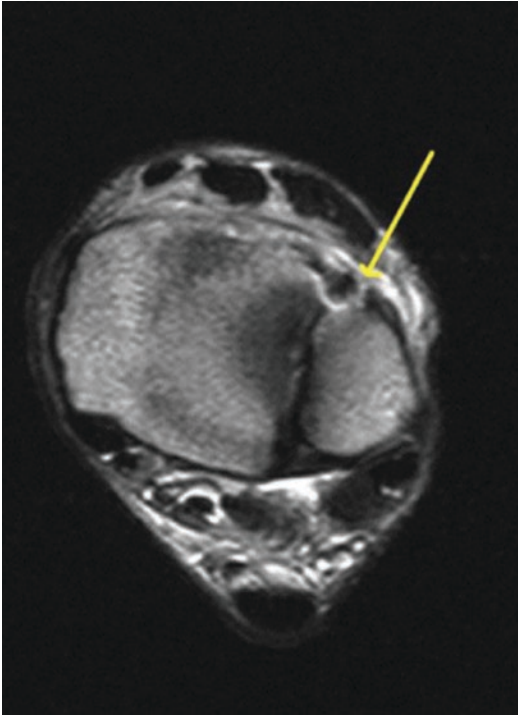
Axial MRI image of an AITFL rupture in an elite football player
